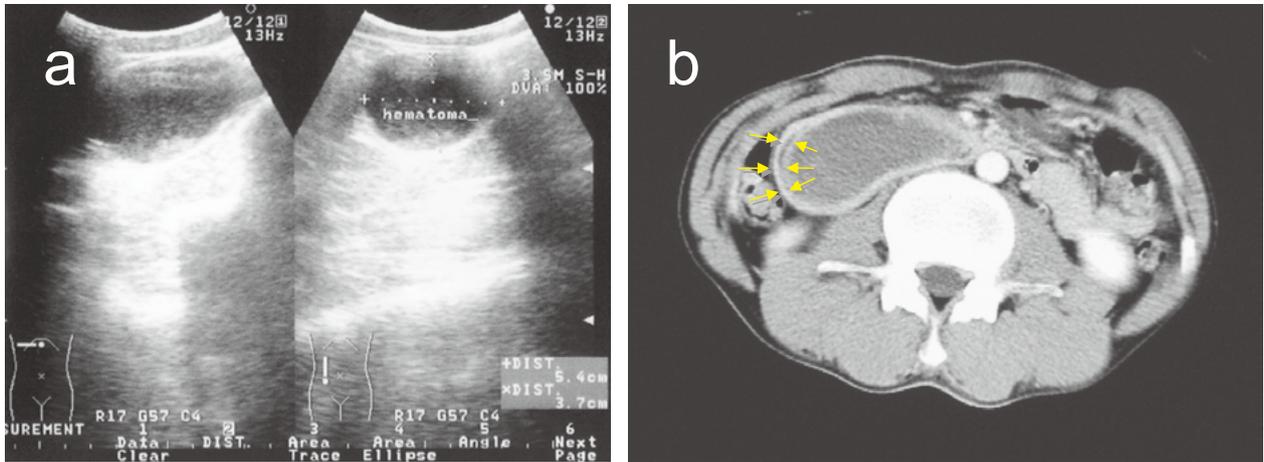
a. Abdominal ultrasonic image (US) exhibits a cystic lesion (5.4 x 3.7 cm) at the second to a third portion of the duodenum. There are high echogenic substances at the cystic bottom probably corresponding to the coagulated blood. b. The contrast enhanced abdominal computed tomography (CT) shows the same cystic lesion located at the duodenum with a fluid-to-fluid level formation inside. The narrow portion that is surrounded by *yellow arrows* is the true duodenal lumen.
